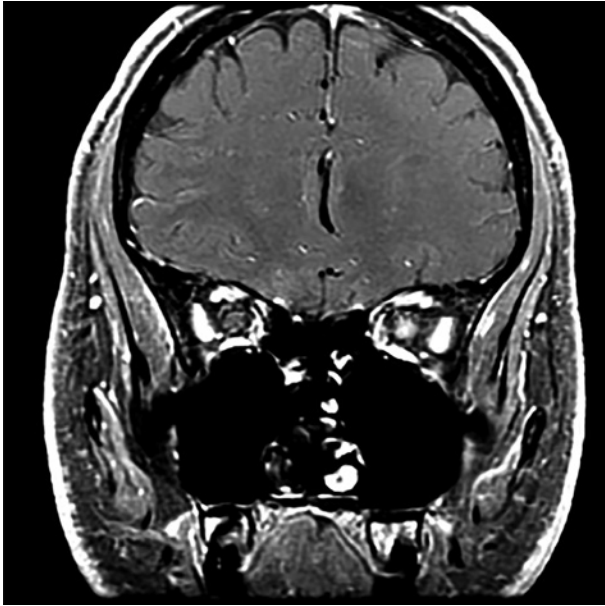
Coronal T1-weighted MRI of the orbits with fat suppression shows enhancement of the left intraorbital optic nerve in a patient with optic neuritis.
